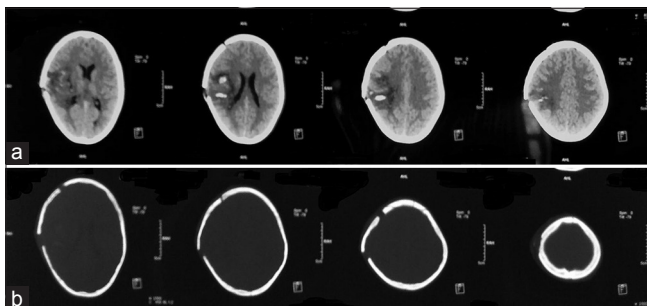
(a) Noncontrast Computed Tomography brain showing elevated fracture of the right parietal bone with intracranial hematoma, (b) Noncontrast Computed Tomography bone window showing right parietal bone elevated fracture
